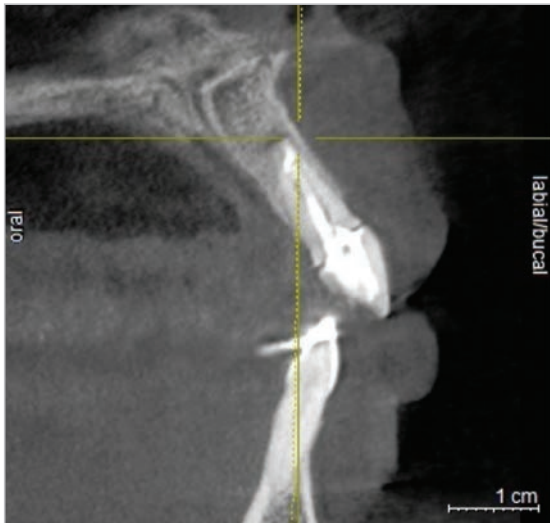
CBCT showing the situation before the extraction and after the extraction and implant placement. Note presence of buccal bone plate in both images.
